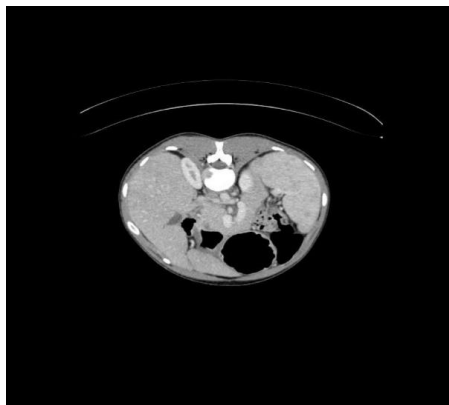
Delineated, nodular intensities in the right lobe of liver at venous phase of Abdominal CT, Axial image.
